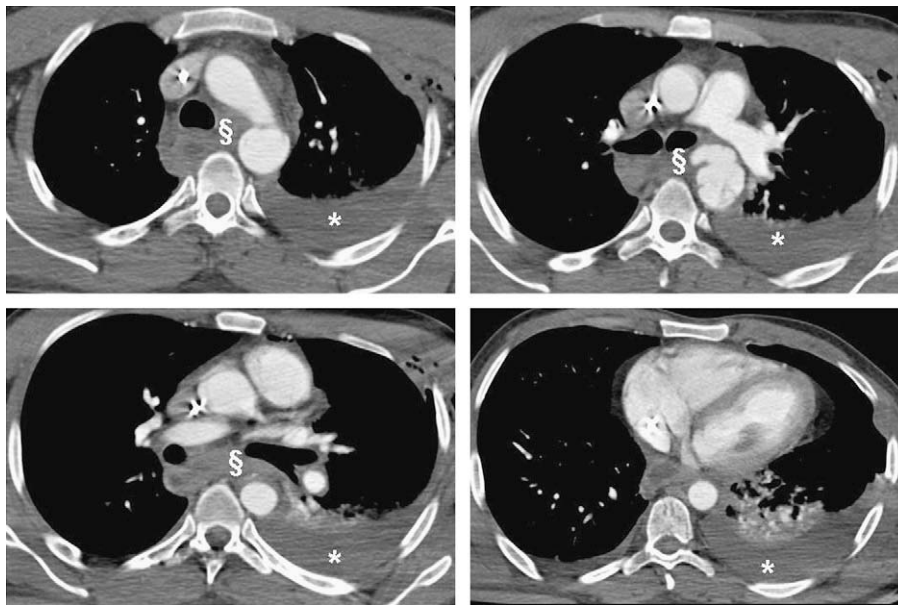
Axial CT images of an aortic isthmus rupture with aortic wall discontinuity, periaortic mediastinal hematoma (§) and pleural effusion (*) with associated lung atelectasia.
